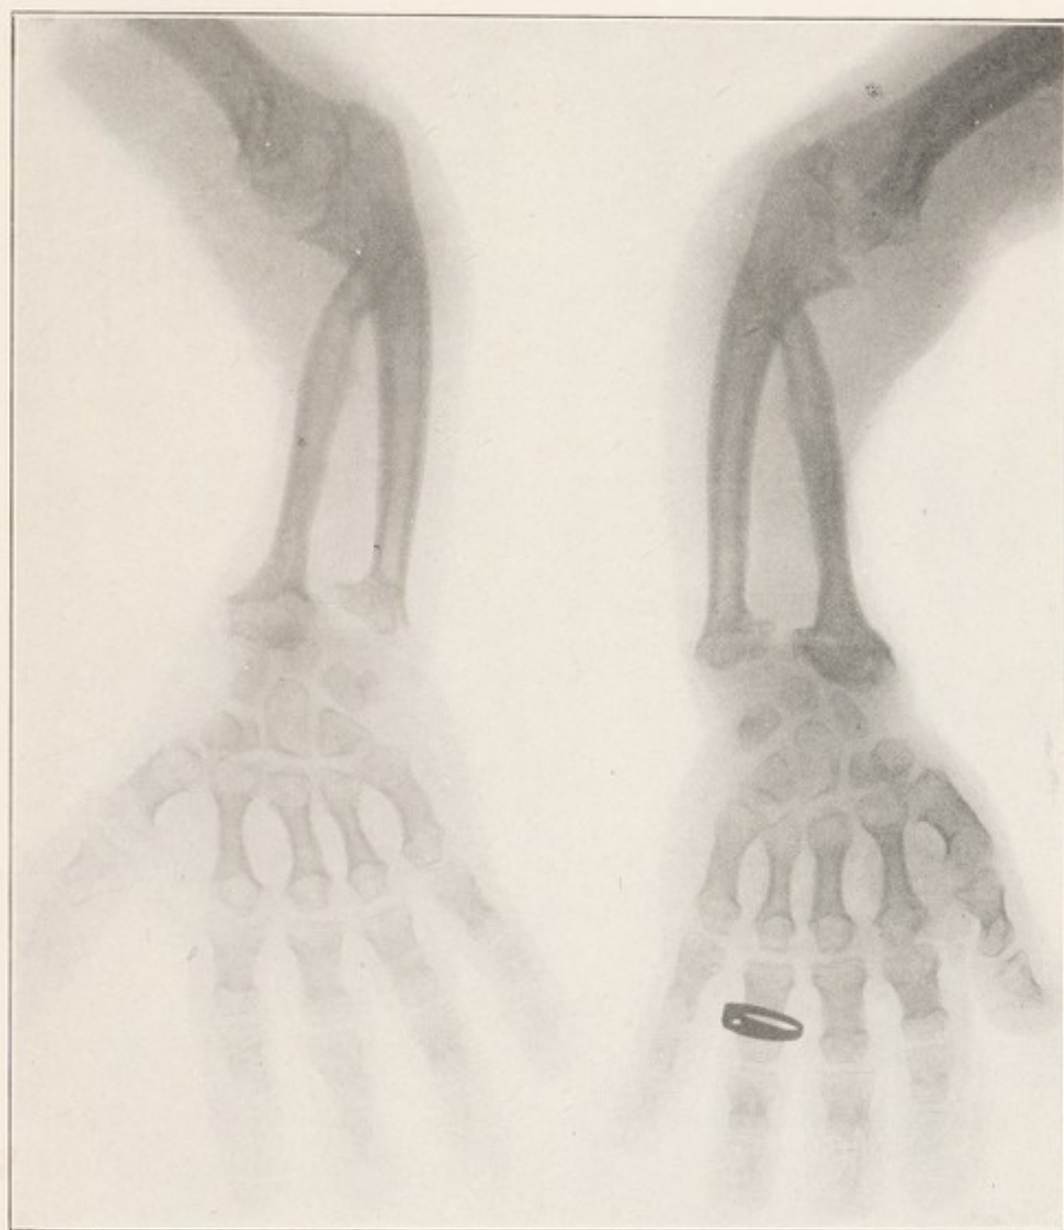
X-RAY OF BONES OF FOREARMS, SHOWING CHANGES IN CHONDRODYSPLASIA FETALIS.
